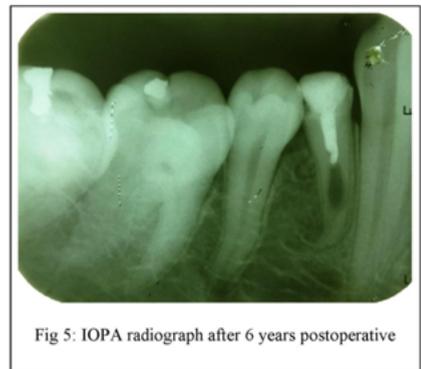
IOPA radiograph after 6 years postoperative
